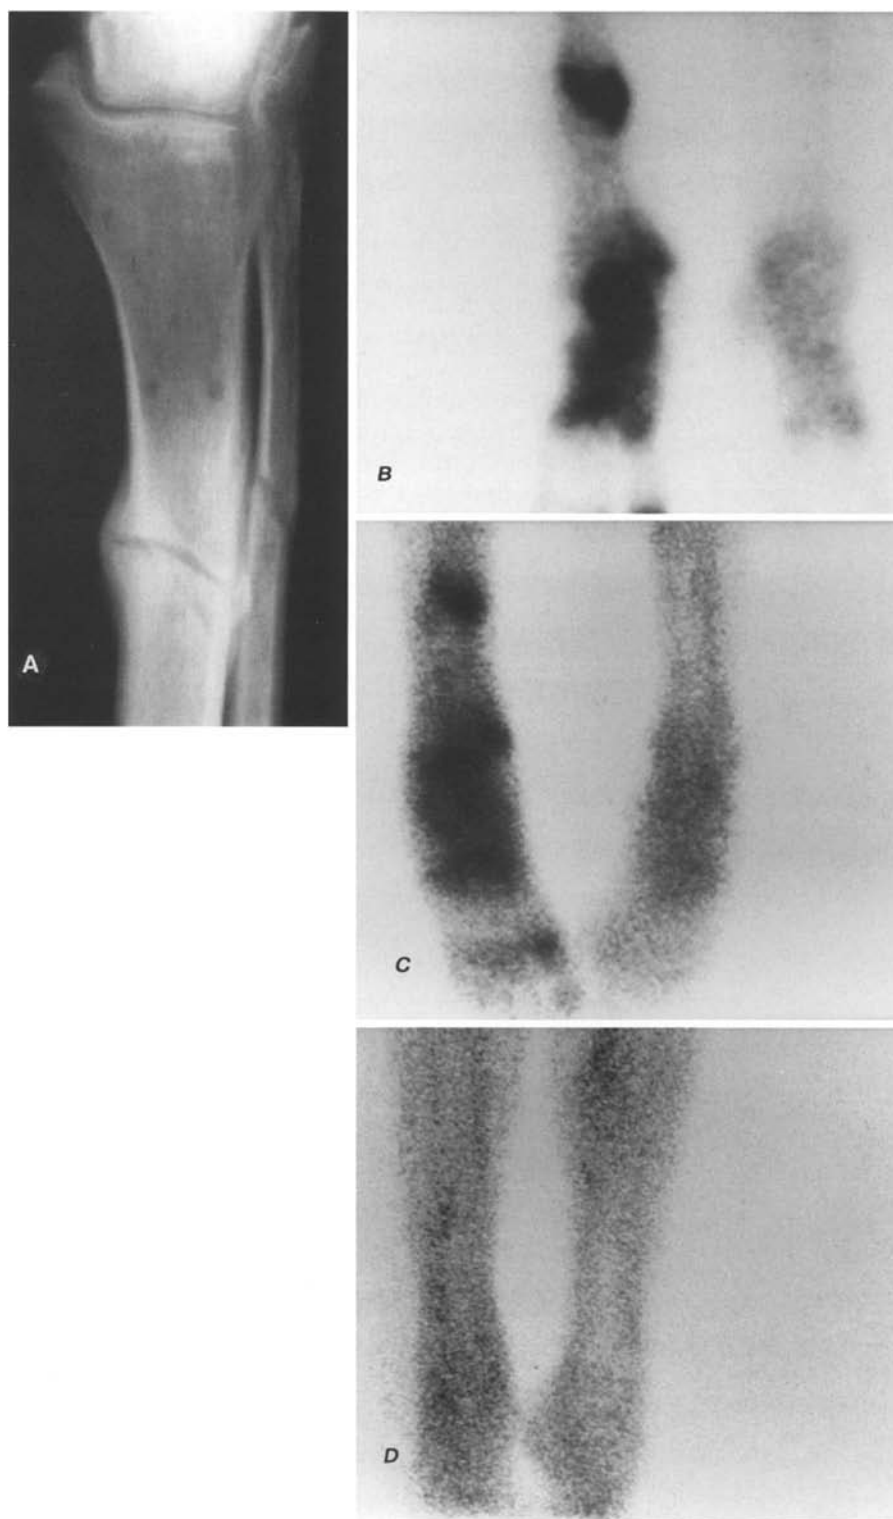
Twenty-three year old patient after tibial fracture. One year after primary surgery and metal removal he still suffered from pain and swelling. Planar X-ray shows the fracture with the diagnosis of pseudoarthrosis, but osteomyelitis could not be excluded (a). Bone scintigraphy demonstrated increased mineralization in the old fracture and the foot (b). ^{99m}Tc -antigranulocyte antibody scan demonstrated nearly comparable information with the suspicion of infection (c). ^{99m}Tc -HMPAO white blood cell scan was completely negative (d). Surgery excluded infection 5 days later
